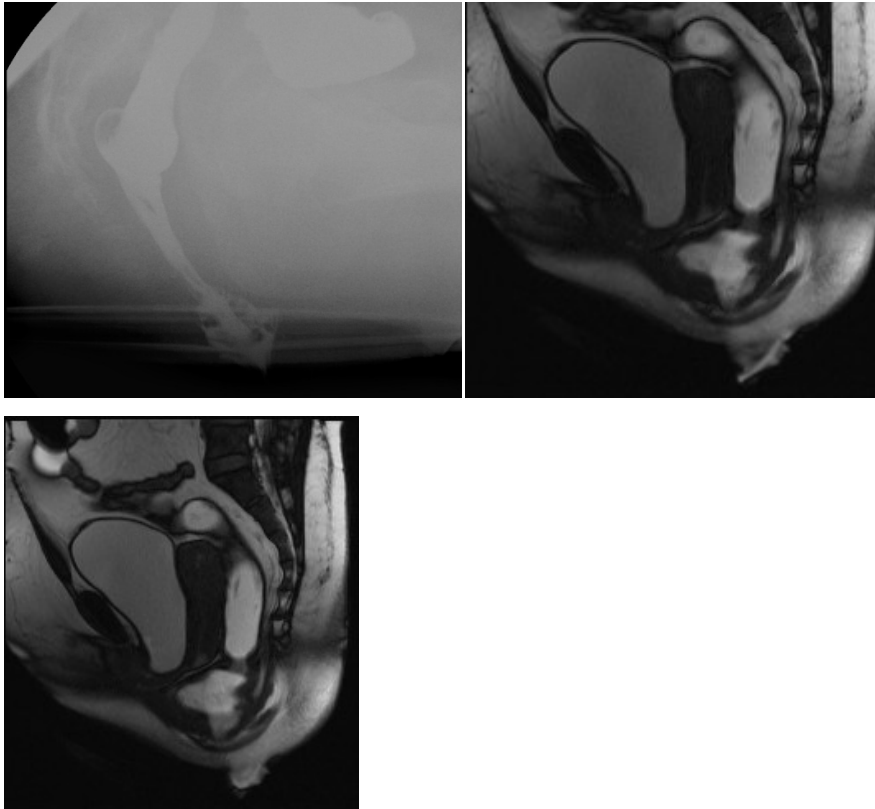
Intra-rectal intussusception seen on the barium defecogram and MRI defecogram of one of the participants
